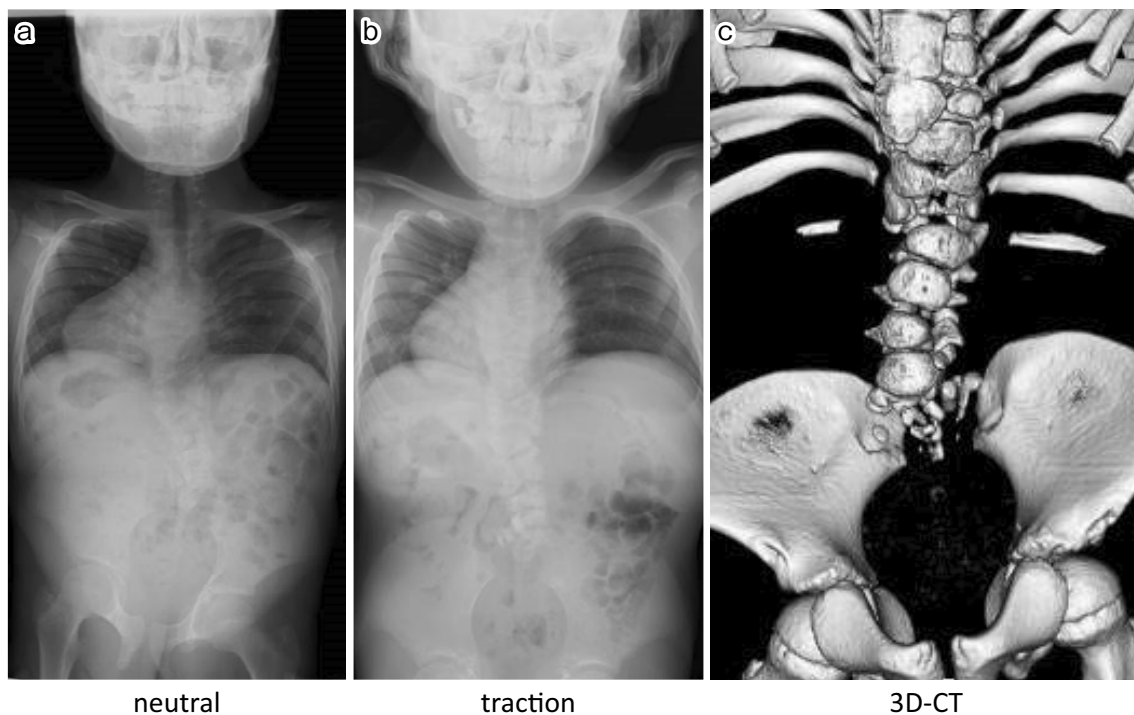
X-ray and 3D-CT images showing the characteristics of the articulation between the spine and the pelvis based on Renshaw type III. a, neutral position; b, manual traction showing a telescoping sign; c: congenitally deformed lower lumbar vertebrae descending into the gap between the bilateral ilia.
